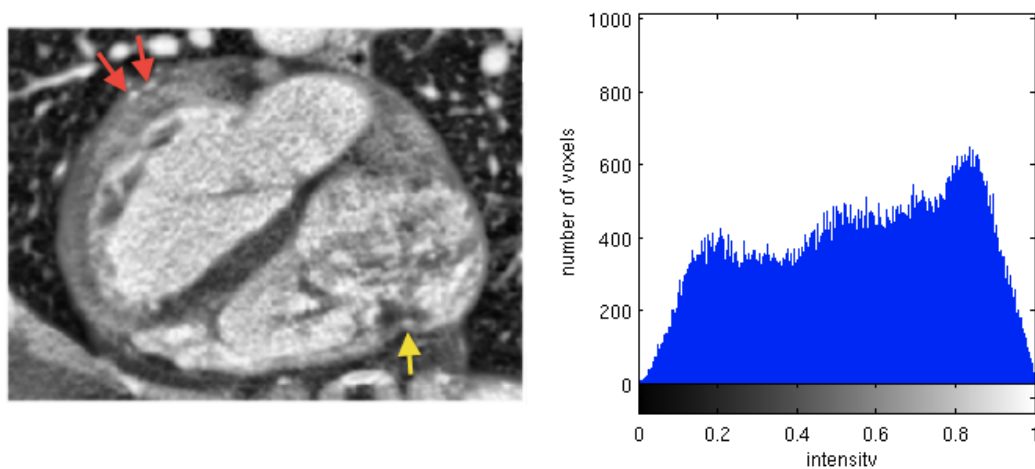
CTA image after CLAHE using  $8 \times 8 \times 8$  contextual regions (left) and its histogram (right).
